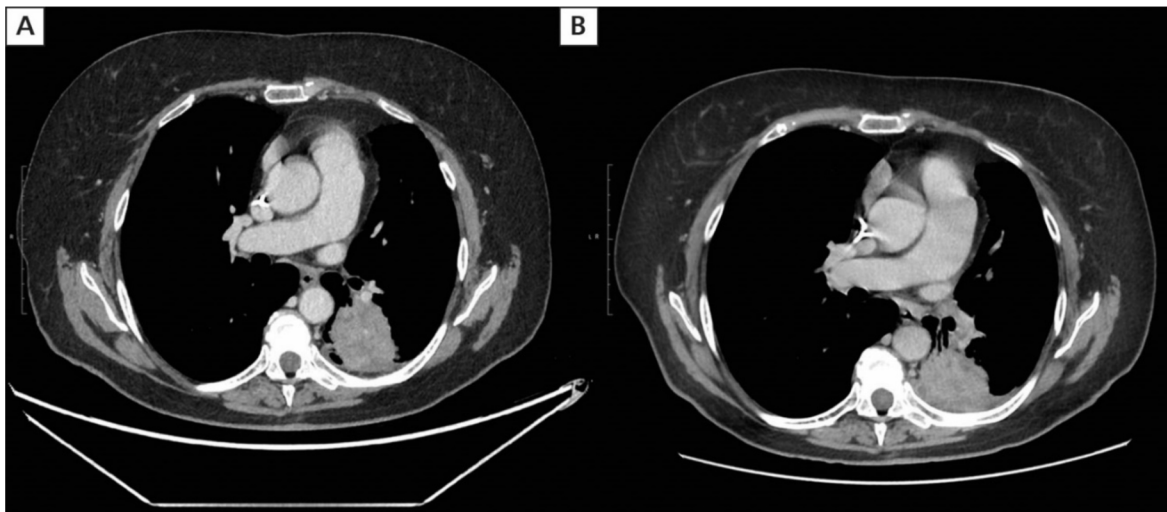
A. May 2021. High-resolution computed tomography of the chest showing disease progression after chemotherapy. B. August 2021. High-resolution computed tomography of the chest showing stabilization of lung tumor size after 7 cycles of nivolumab immunotherapy
